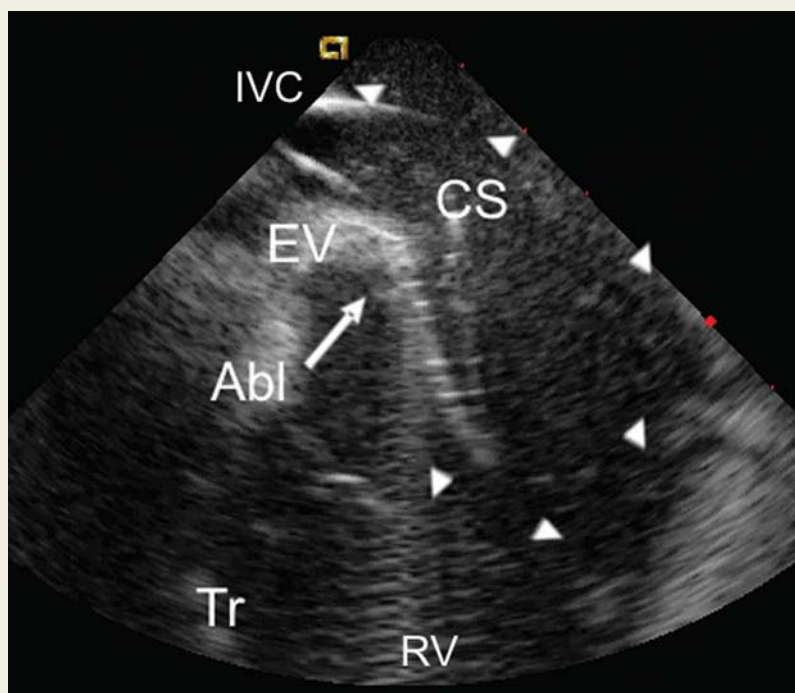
An intracardiac echocardiographic picture presenting a prominent, muscular, and actively contracting Eustachian valve (EV), which could only be engaged by curving the ablation catheter (Abl) into full circle (arrowheads) to touch the anterior surface of the valve. Muscle fibres running in the EV were likely responsible for resistant transisthmus conduction. CS, coronary sinus; Tr, tricuspid valve; IVC, inferior vena cava; RV, right ventricle.
